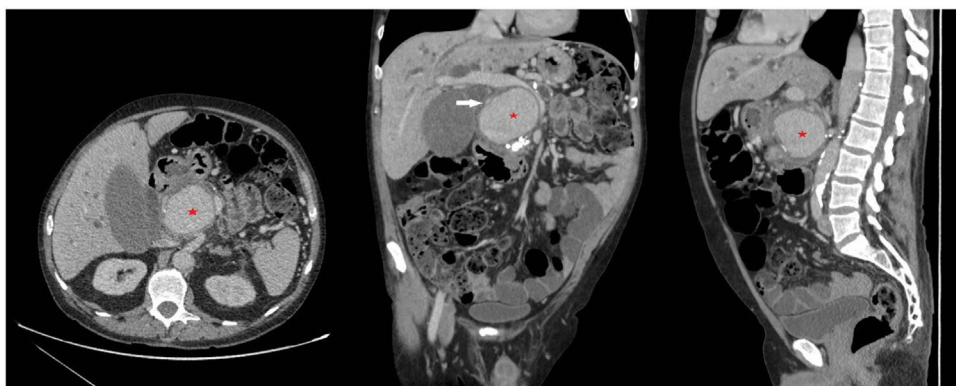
CT scan of abdomen and pelvis with intravenous contrast administration (axial, coronal and sagittal view): marked dilation of the intra- and extrahepatic bile duct due to extrinsic compression of the common bile duct secondary to an 8 × 5 cm mass located at the head of pancreas, with IVC inside and well-defined walls compatible with a pseudoaneurysm (*) originating from the hepatic artery (arrow).
